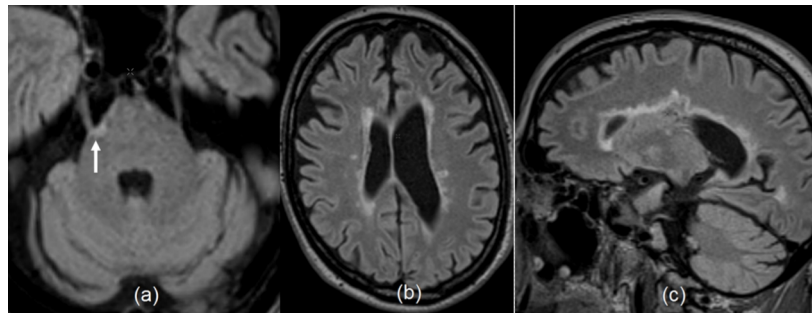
An elderly patient treated for MS decades ago with no previous imaging, presented with right trigeminal neuralgia. (a) 3D FLAIR axial reconstruction through brainstem shows a lesion at the attachment of right trigeminal nerve (white arrow). Further reconstructions of 3D FLAIR (b,c) show multiple periventricular lesions, some of these are suggestive of MS
